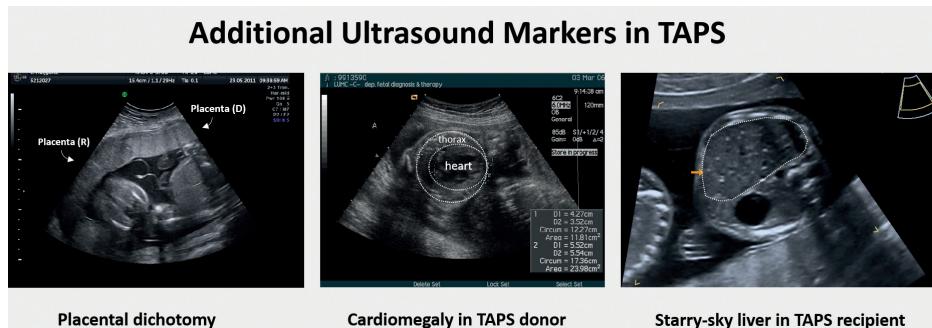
Ultrasound images of placental dichotomy, cardiomegaly in the donor, and starry-sky liver in the recipient in pregnancies with twin anemia polycythemia sequence (TAPS).
